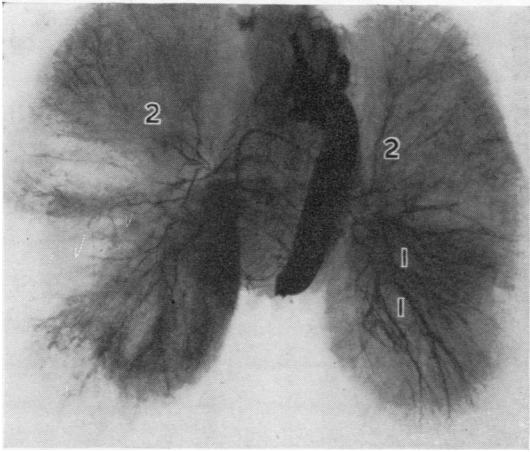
Case 14: radiograph of both lungs. The aberrant course of the bronchial arteries in the left lower lobe is shown: 1, anastomoses with the peripheral branches of the pulmonary arteries; 2, constricted bronchial arteries to both upper lobes.
